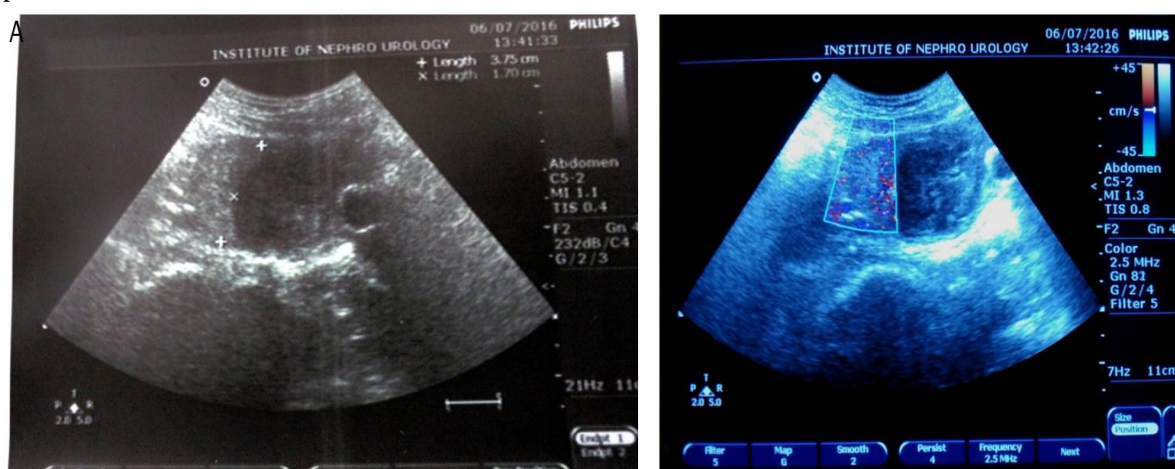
Pelvic ultrasonography of the urinary bladder. (A) Intravesical clot with a hyperechoic area at the bladder dome measuring approximately 3.3×1.7 cm. (B) Colour Doppler interrogation demonstrating mild vascularity within the dome lesion. Both kidneys were normal without hydronephrosis or calculi.
